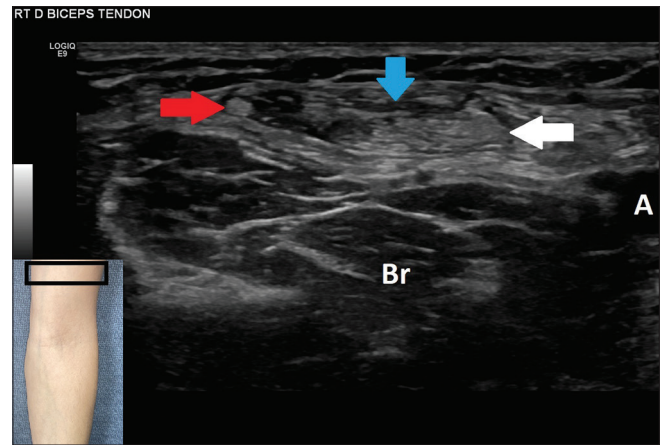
Transverse ultrasound image of the musculotendinous junction (blue arrow) demonstrating the short head component (white arrow) and long head component (red arrow) as two distinct structures. The short head component (white arrow) was the ruptured element of the bifid distal biceps tendon. Br: Brachialis muscle, A: Brachial artery
